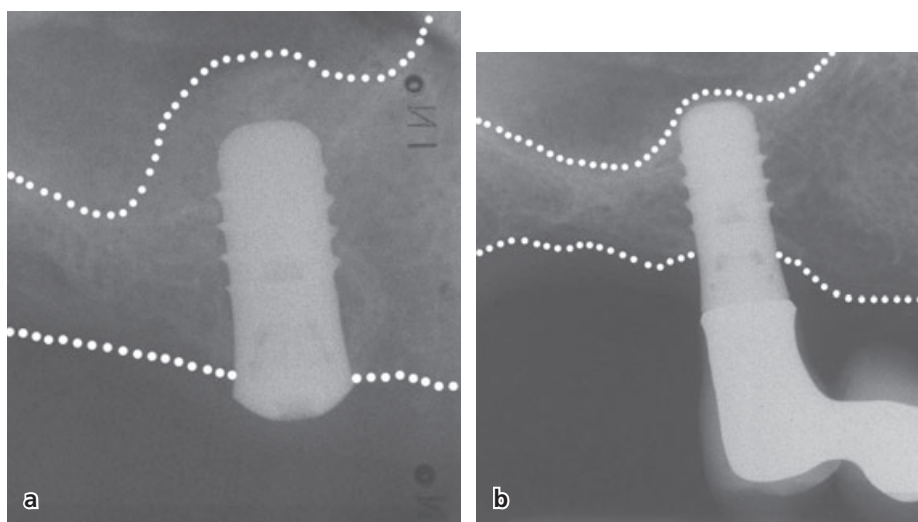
(a) Radiograph taken immediately after implant insertion with the osteotome technique and grafting material, showing a cloudy dome-shaped structure extending 2–3 mm apical to the implant. (b) Radiograph of the same implant taken 1 year later showing significant reduction of the size of the “dome”, but the new bony structure is clearly visible apical to the implant (the dotted lines represent the outlines of the grafting material and the residual bone).
